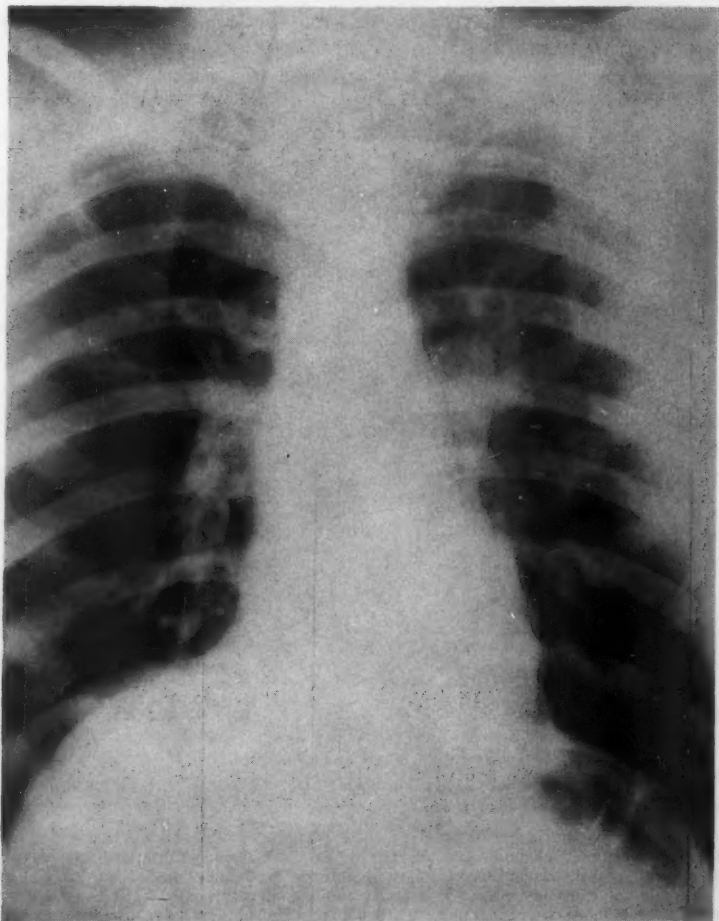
The roentgenogram after radiation, showing regression of the mass except for a residual slight widening of the superior mediastinum and the left hilar area.
